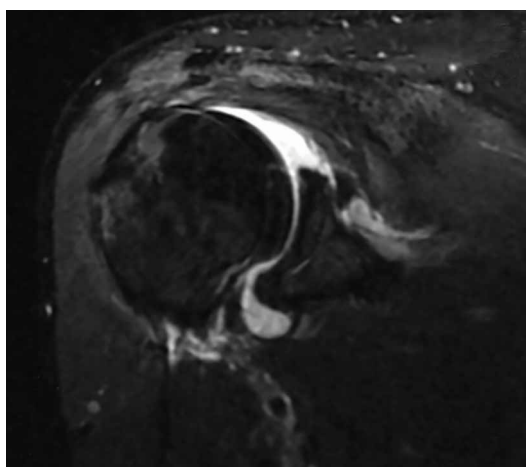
Twelve weeks after injury, coronal T2-weighted magnetic resonance arthrography shows partial reorganization of humeral avulsion of glenohumeral ligament lesion.
